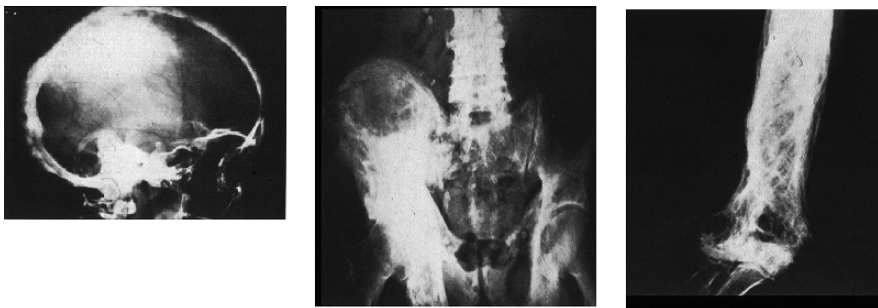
Typical x-rays showing pagetic lesions in the skull, pelvis, and arm
